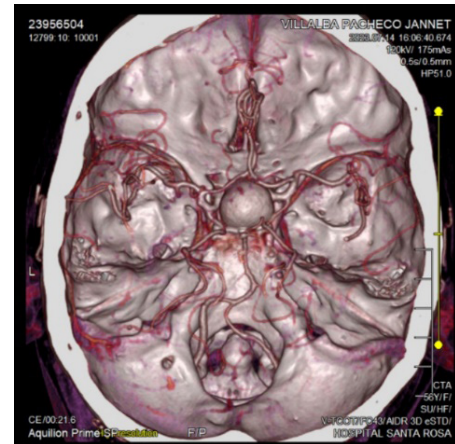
CT angiographic reconstruction of the brain. Approximate measurements of 20.6 x 1.6 x 16.7 mm in the anteroposterior, transverse and craniocaudal dimensions, with involvement of the sella turcica and originating from the right internal carotid artery.
